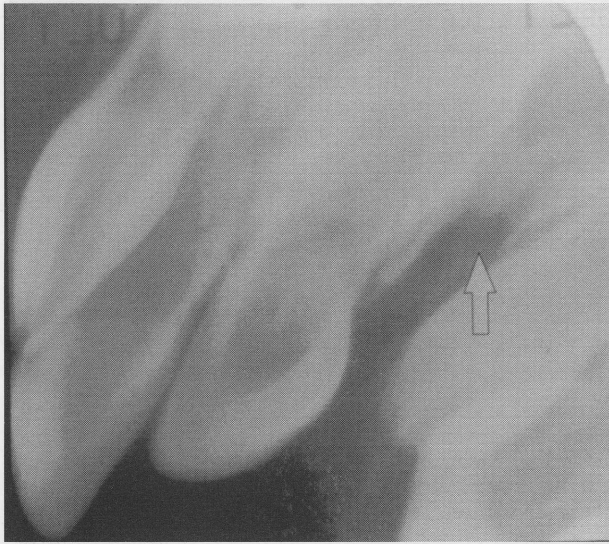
Radiograph of a repaired alveolus at age 7, revealing bone growth within the cleft (arrow).
